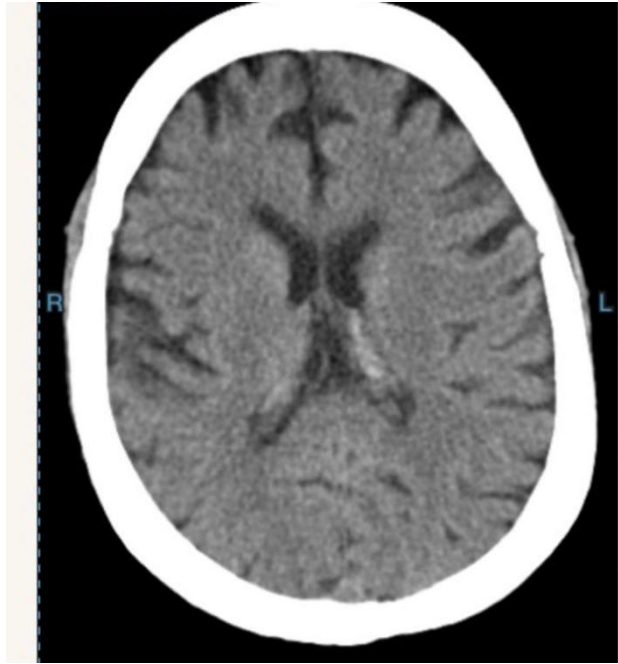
Showing CT Scan of the case with no obvious abnormality
